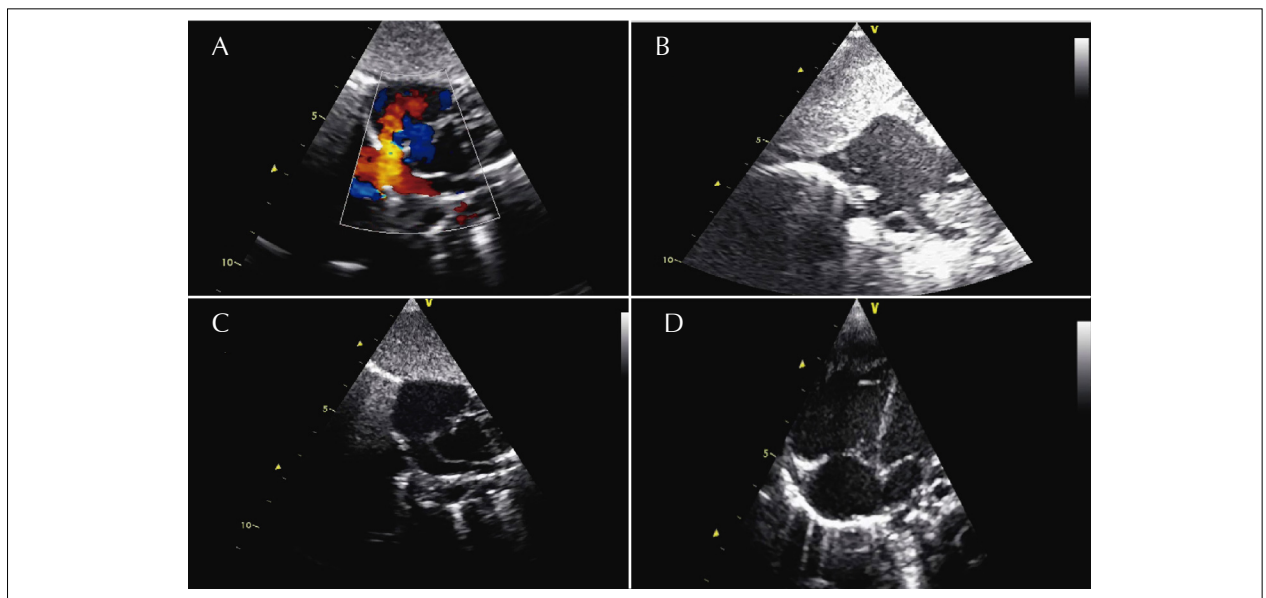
A) Subcostal view of transthoracic echocardiography with color Doppler revealing right-to-left shunt in the atrial septal defect (blue) and an anomalous pathway from a retro-atrial conduit emerging into the right atrium (red); B) Subcostal “bicaval” view with a right merging vasa in the superior vena cava just before entering the right atrium; C) Anomalous retro-atrial conduit emerging into the right atrium; D) Apical four chamber view with dilated right sided chambers.
